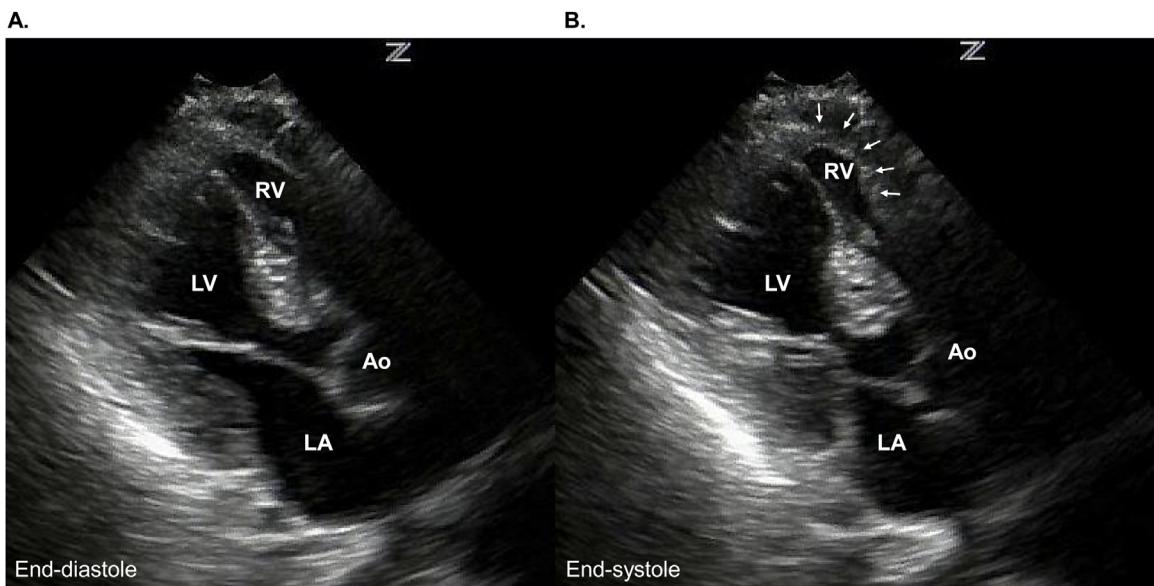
Biventricular takotsubo syndrome. Apical long-axis view of the echocardiography [end-diastole (A) and end-systole (B)] demonstrates akinesis of LV and RV (arrows). Ao, aorta; LA, left atrium; LV, left ventricle; RV, right ventricle.
